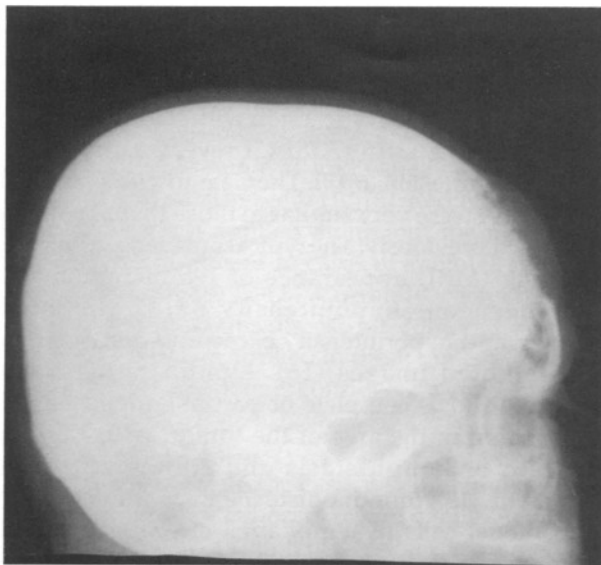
Lateral and anteroposterior radiographs of the skull reveal an expanding radiolucent mass in the frontal bone. The described radiating hyperdense areas are visible.
